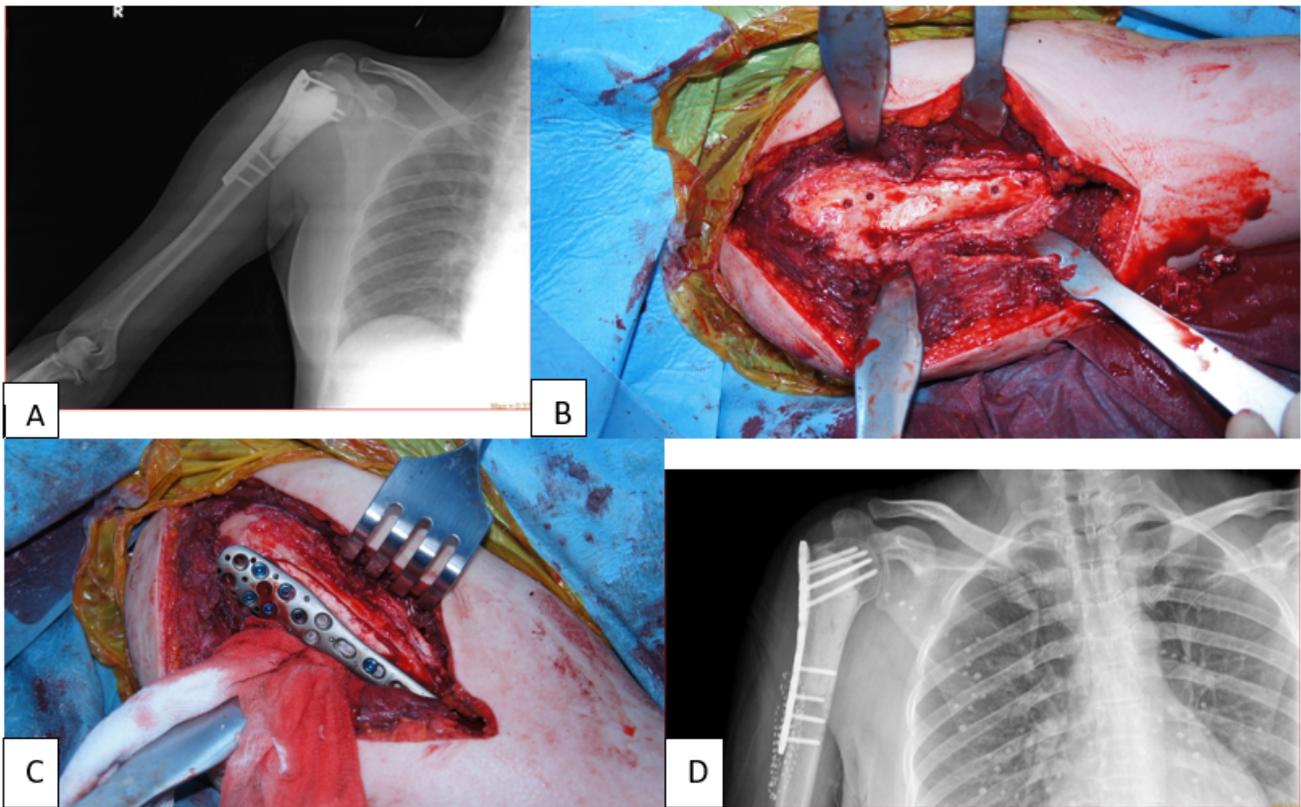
Patient with a recurrence. (A) Postoperative x-ray after the initial procedure. (B) Intraoperative image shows the recurrence focus beneath the plate. (C) After curettage and plate fixation. (D) X-ray after second intervention.
